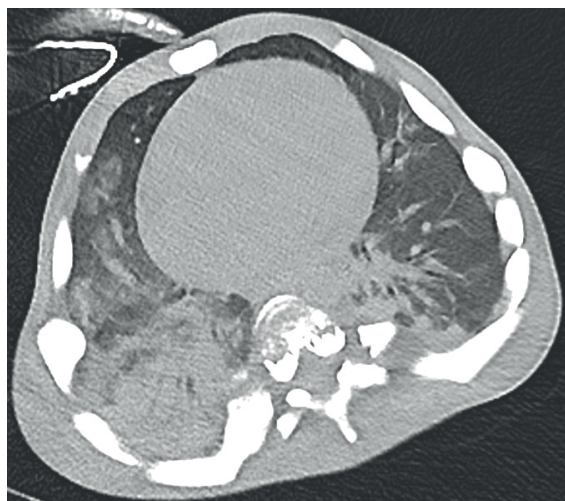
A-13-year-old girl with COVID-19 pneumonia. Axial non-contrast enhanced chest CT image demonstrates diffuse consolidation in the right lower lobe, peribronchial patchy ground-glass opacities in the right middle lobe, and subpleural consolidation in the left lower lobe. Note that the diffuse osteosclerosis of all bony structures in the thoracic cage is compatible with osteopetrosis.
